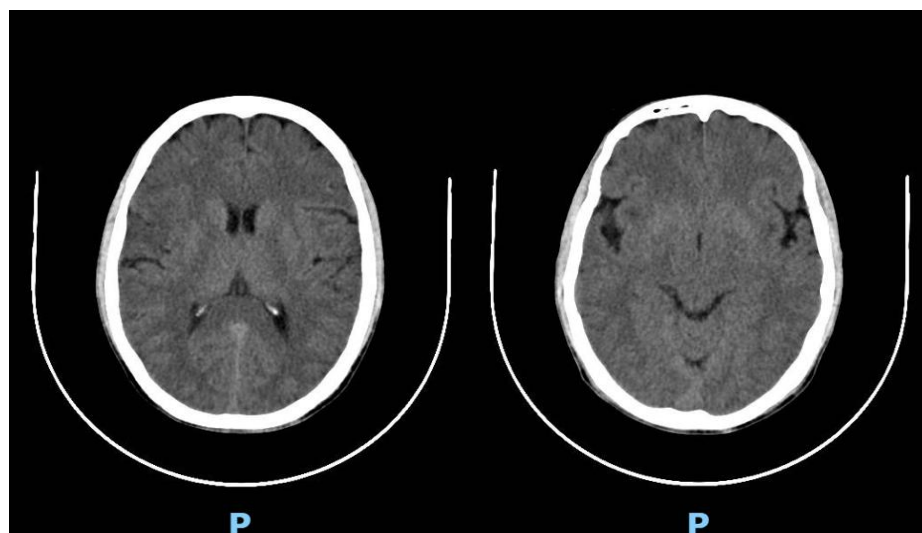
CT-head non-contrast during treatment one month earlier for ischemic stroke. A lacunar infarct was found in the right insular region.
